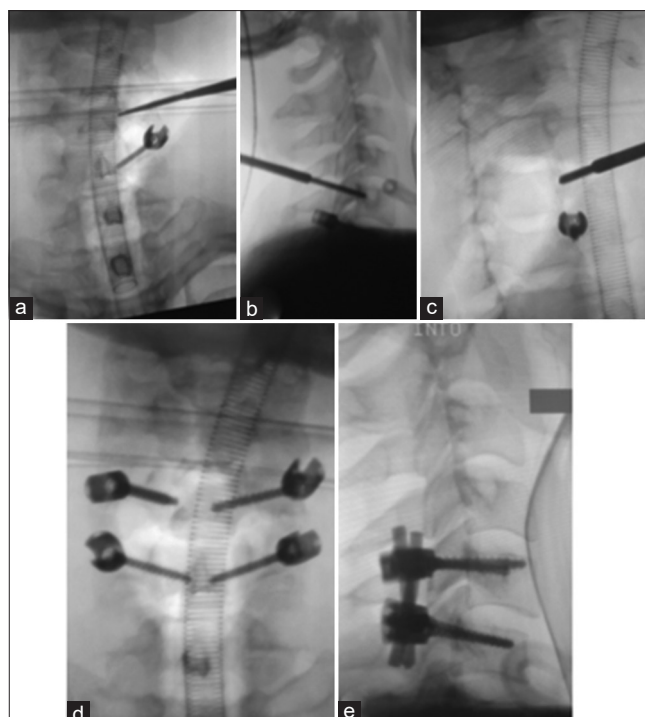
“Pedicle Axis View” instrumentation technique. (a) Anteroposterior fluoroscopic image of the cervical spine, with a probe positioned in the medial cortex of the pedicle, (b) Lateral fluoroscopic image demonstrating probe positioning at the junction of the pedicle with the vertebral body, in agreement with the previous image, (c) True anteroposterior fluoroscopic view of the pedicle, obtained at a 30°–55° angle of the device. It is observed that there is no violation of the medial cortex of the pedicle, (d) Anteroposterior fluoroscopic image with the 4 screws properly positioned, (e) Lateral radiography image performed after placement of nails and blockers
